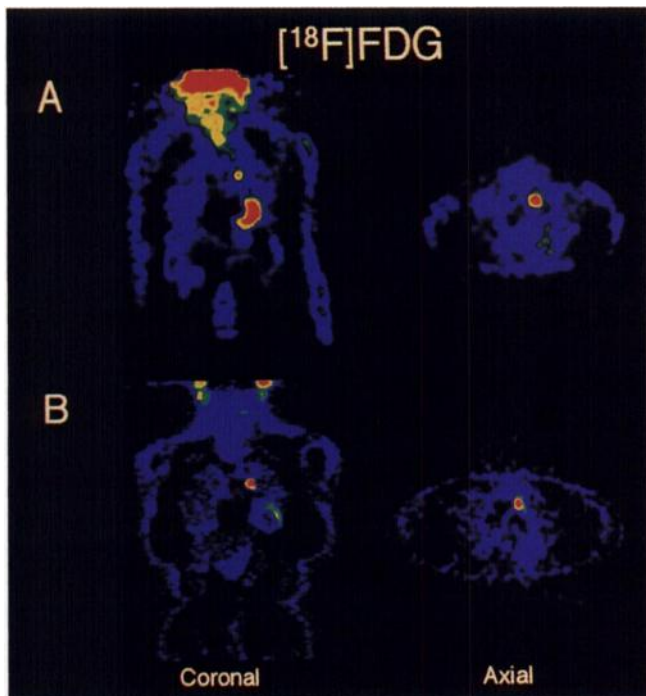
This 58-y-old woman had breast cancer surgically treated 2 y before PET study. Progressive increase of tumoral marker CA 15.3 had been observed over 3 mo preceding PET study. MRI showed 1.2-cm internal mammary lymphadenopathy. Both DH-PET (A) and Ring-PET (B) show lesion with high metabolic activity, consistent with lymph node involvement.
